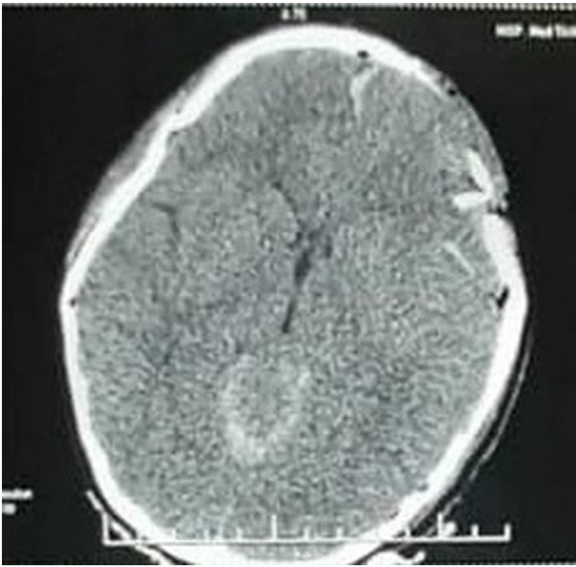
Axial section of a brain CT scan showing a depressed frontal fracture with subarachnoid haemorrhage, and a subdural haemorrhage of the falx cerebri.
